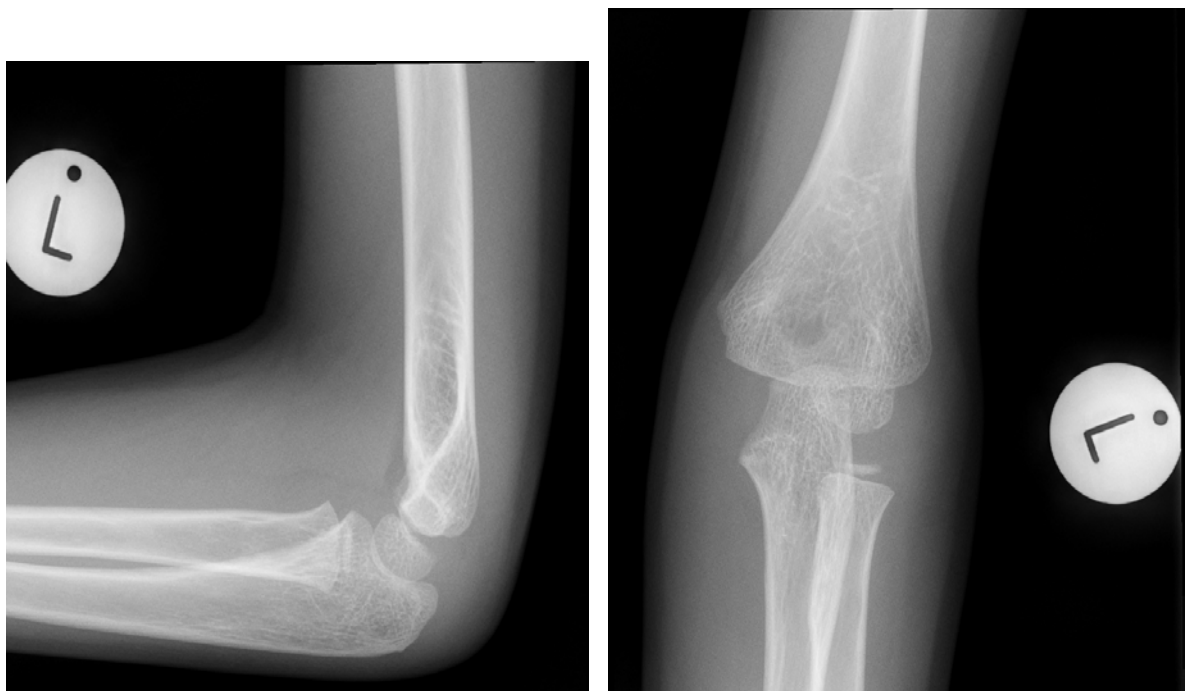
Lateral and AP radiographs of slide 8 (post tutorial)
